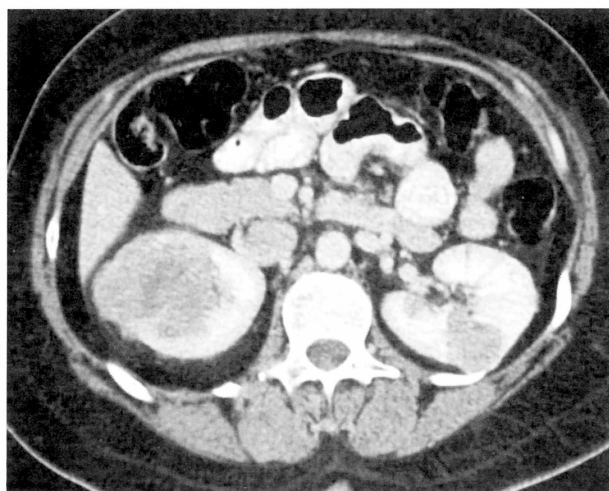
CT scan of the abdomen showing bilateral renal metastases.
